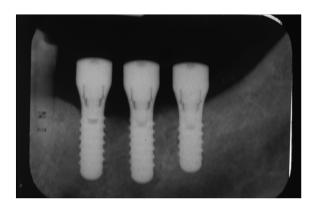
Six months post-corrective surgery. Radiograph shows improved bone radiodensity around implants #19 and #20.
